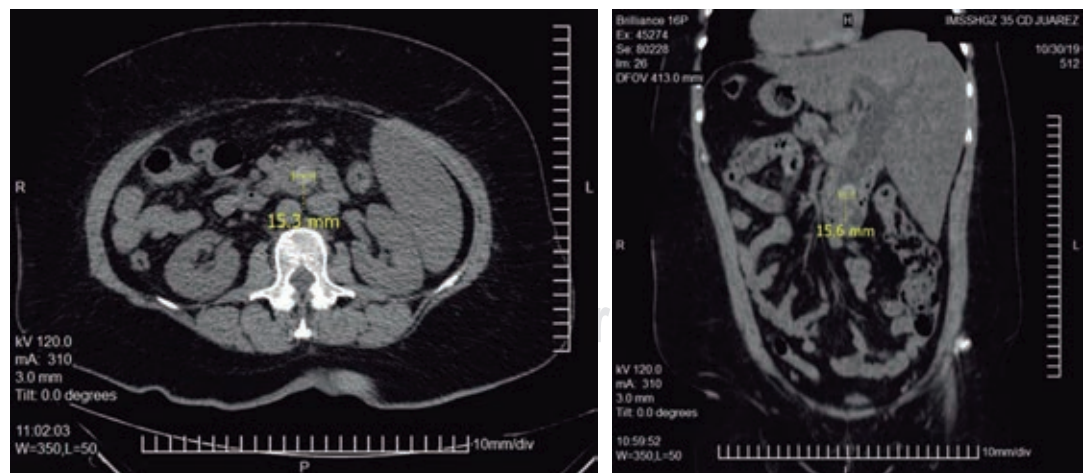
Axial and coronal CT scan confirming the diagnosis of *situs inversus totalis* and showing dilatation of the bile duct and a 15 mm lithiasis.
